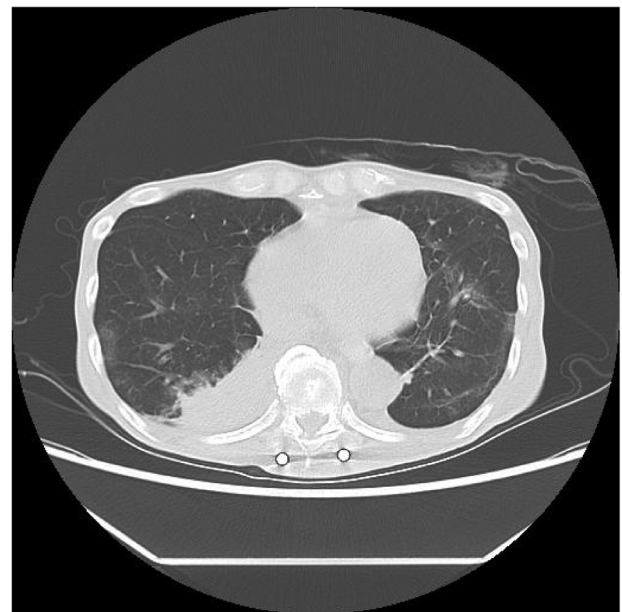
Computed tomography image taken 16 days after infection with SARS-CoV-2 in a 50-year-old man after combination therapy with nivolumab and ipilimumab for metastatic renal cell carcinoma. Ground-glass opacity can be observed in the bilateral lower lobes of the lungs.
